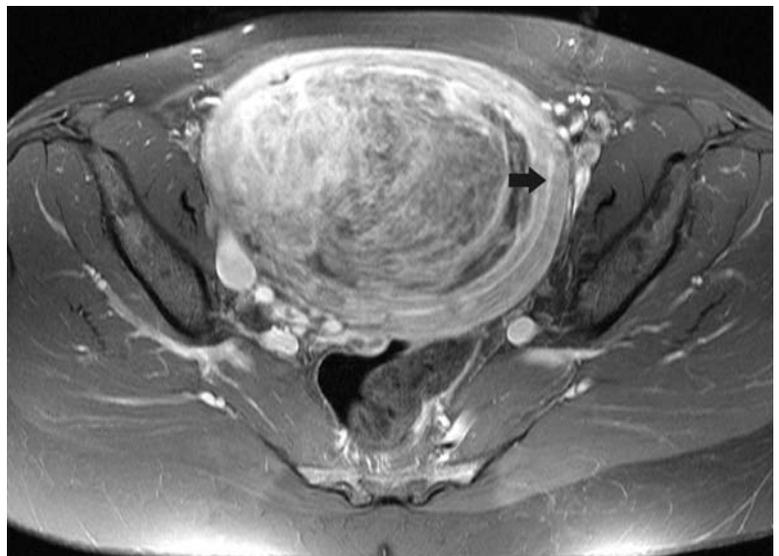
a,b MRI of myxoid leiomyoma. a T2-weighted transaxial image of the uterus showing also heterogenous signal intensity of the leiomyoma and a c-shaped area at the left border of the leiomyoma (*arrow*) of high signal intensity corresponding to myxoid degeneration. Note high signal intensity stripe of the endometrium is displaced laterally. b On the corresponding T1-weighted fat suppressed transaxial image the whole leiomyoma has a heterogenous intermediate signal intensity and the c-shaped area shows no low signal as expected if liquification had occurred. c Contrast-enhanced T1-weighted fat suppressed transaxial image shows heterogenous enhancement of the leiomyoma including septations of myxoid tissue, Note enhancement of endometrial stripe (*arrow*)
